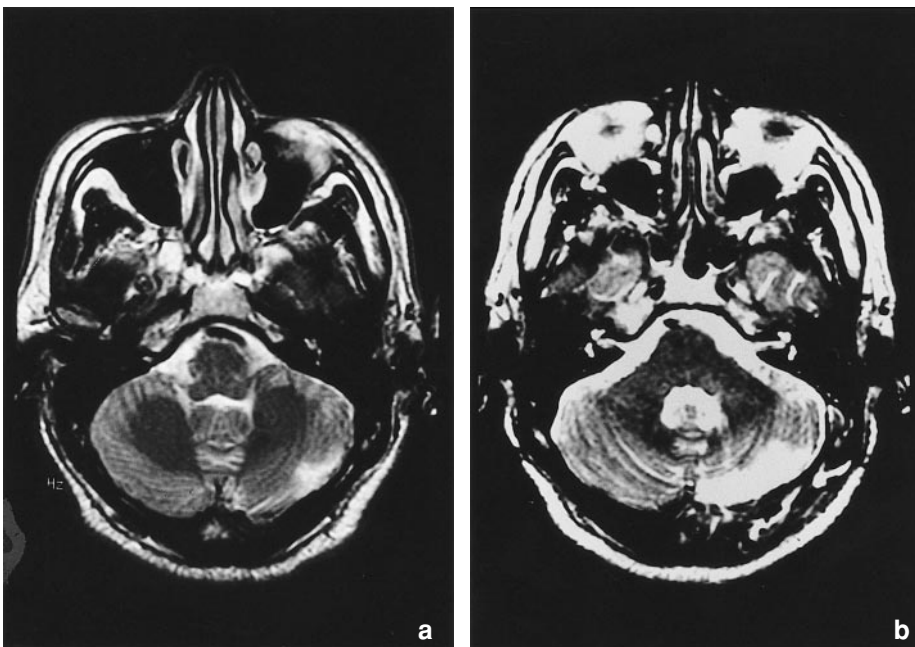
T2-weighted magnetic resonance images, axial views, demonstrating a high intensity area in the left dorsal hemisphere the extent of which is larger in the postoperative image (b) than in the pre-operative image (a)
